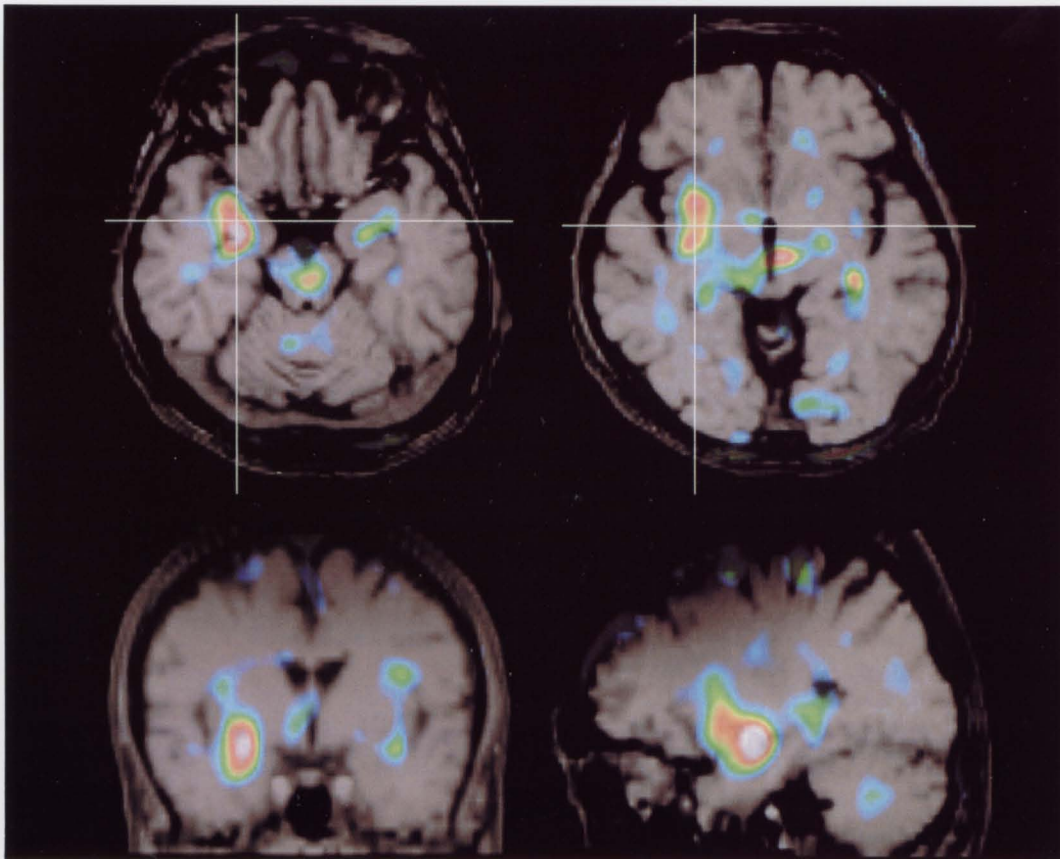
Subtracted postictal-interictal SPECT. Hyperperfusion areas are demonstrated in the right amygdala, hippocampus, insula and ventral putamen. Upper images indicated axial views, and left side of the lower image indicated coronal view, and right side of the lower image indicated sagittal view.
